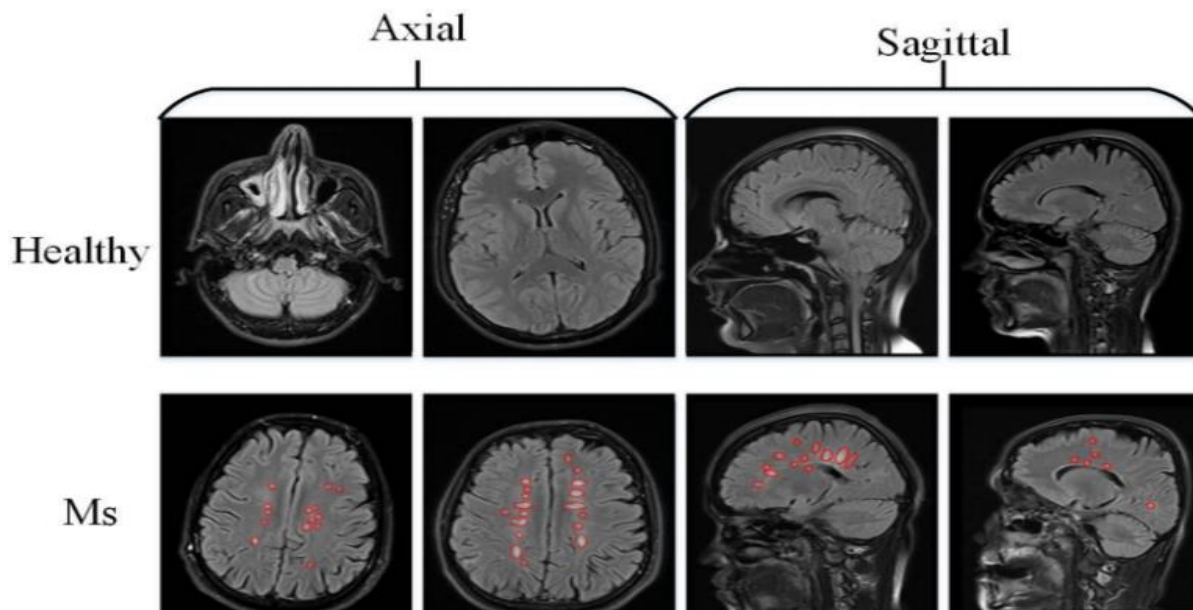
MRI of patient with and without MS.
